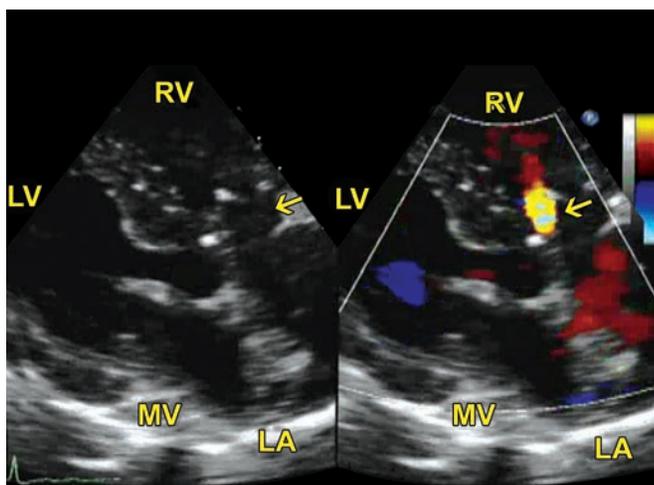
Parasternal long axis view showing membranous VSD (arrow) below the aortic valve.
